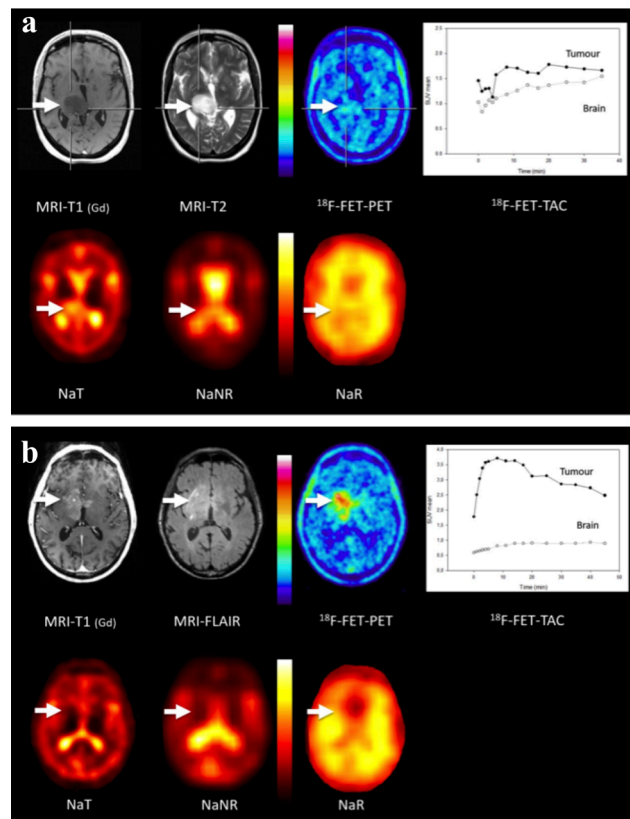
a: MRI and PET of a 52-year-old patient with a diffuse midline glioma WHO grade IV showing IDH wildtype. The tumor (white arrow) shows no contrast enhancement in the T₁-weighted MRI and is clearly depicted in the T₂-weighted MRI. [^{18}F]FET-PET shows no significant tracer uptake in the tumor and an increasing time activity curve. Sodium imaging shows a minor increase of NaT, but no abnormality in NaNR and NaR. b: MRI and PET of a 78-year-old male patient with an IDH wildtype anaplastic astrocytoma WHO grade III in the right basal ganglia. The tumor (white arrows) shows focal contrast enhancement in the T₁-weighted MRI and diffuse abnormalities in the FLAIR image. [^{18}F]FET-PET shows significant tracer uptake in the tumor and a time activity curve with an early peak. Sodium imaging shows no abnormality in NaT, NaNR, or NaR. The signal decrease in the midfrontal area in NaR is due to an artefact caused by air in the ethmoid sinuses.
